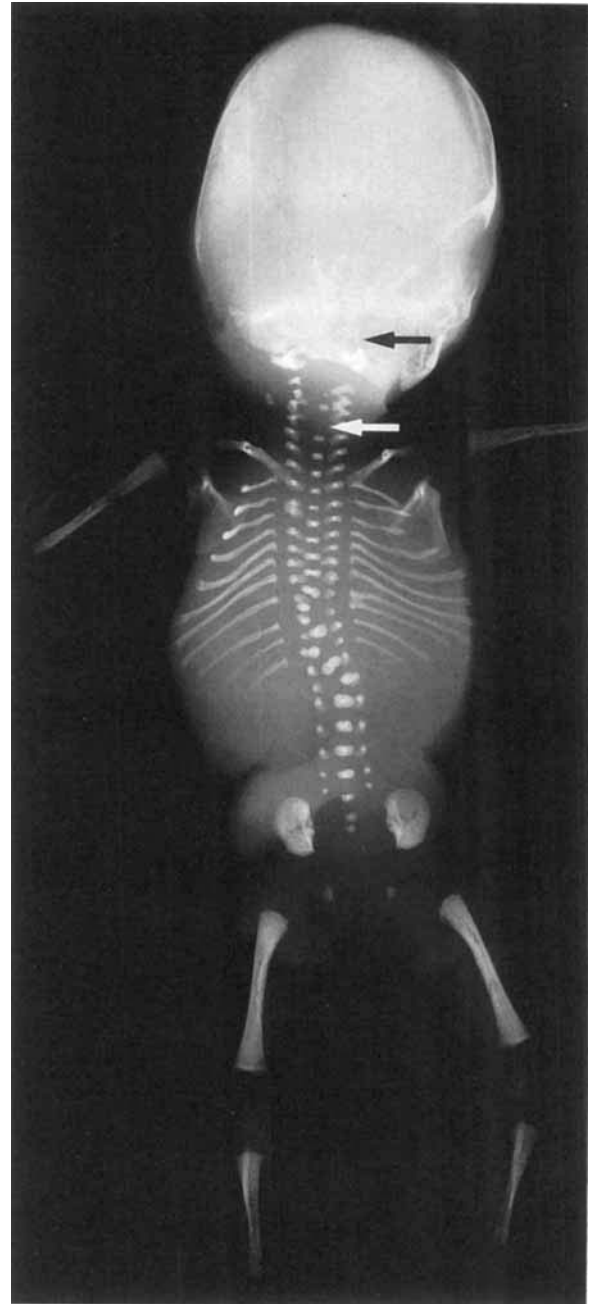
Whole-body radiograph of human fetus with trisomy 18 in frontal view, 18 weeks of gestational age. Note malformed vertebral bodies in thoracic and lumbar regions of the spine. In the cervical spine there is agenesia of a vertebral body (white arrow). The malformed basilar part of the occipital bone (black arrow) is hardly visible in the whole-body radiograph ($\times 0.8$).
